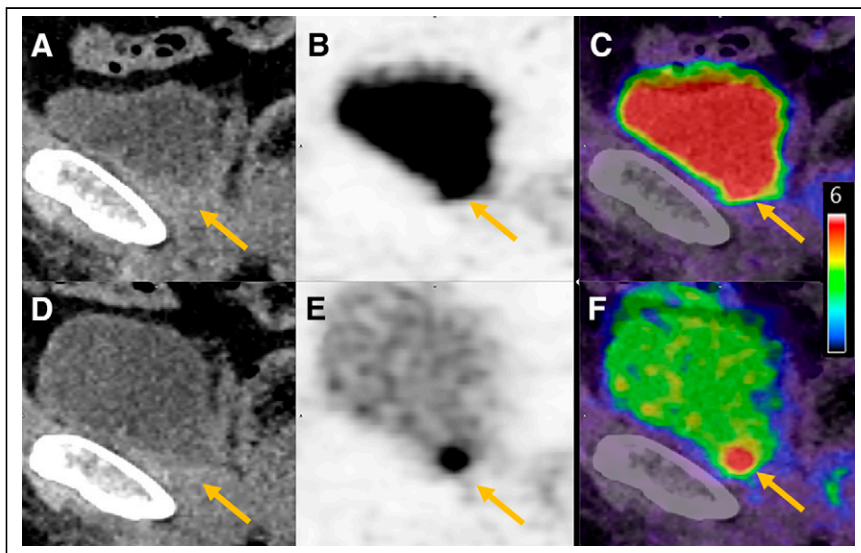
Example patient scan showing locally recurrent lesions (arrows) obscured by high bladder activity in old protocol at late imaging. Shown are low-dose CT (A and D), PET (B and E), and fusion of PET and low-dose CT (C and F) images 2.5 h after injection (A–C) and 1.5 h after injection (D–F).
